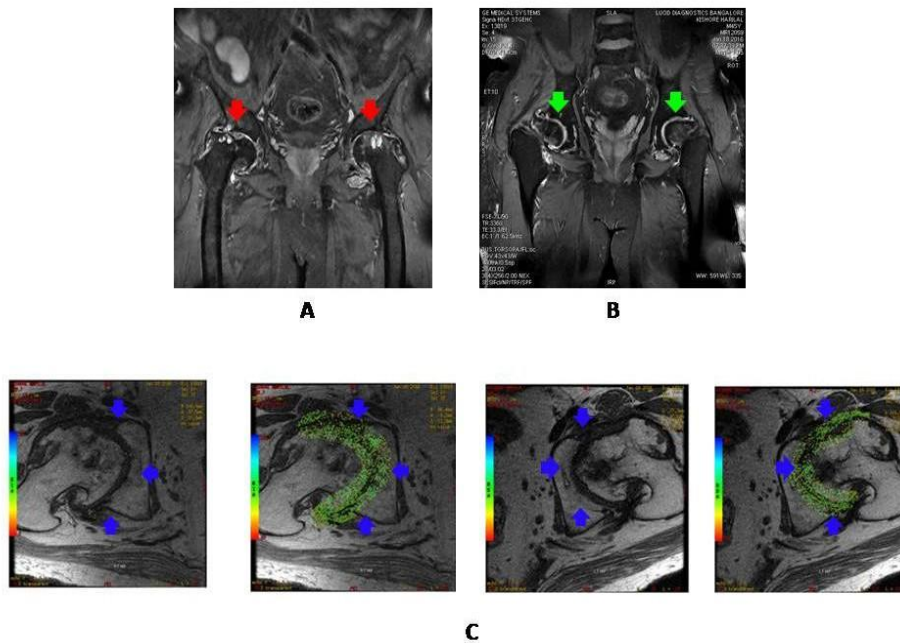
Case 2: MRIs pre- and post-therapy. A (Top Left) - Pre-therapy MRI; B (Top Right) - Post-therapy MRI; C (Bottom 4 images) - Post-therapy cartigrams consisting of alternating images of those with no colors for the lack depiction of hydration within the cartilage and those with colors of cartilage depiction of hydration. Red arrows indicate the location of loss of cartilage and green arrows show the location of the regeneration of cartilage, respectively, in the pre- and post-therapy MRIs; blue arrows show the cartilage location in the cartigrams.
